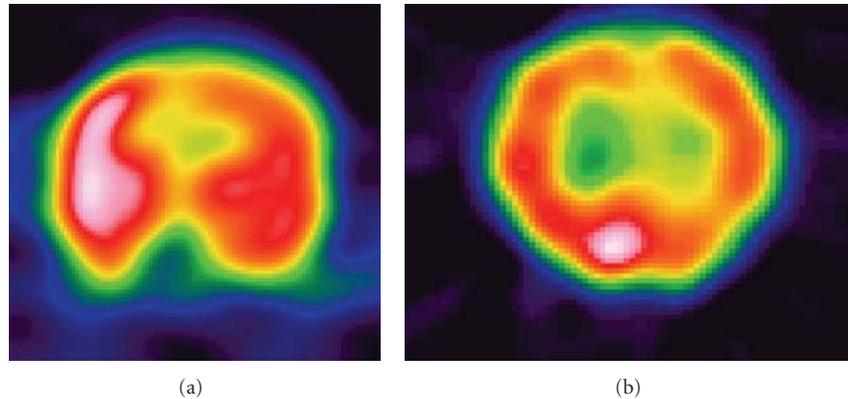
Ictal SPECT in extra temporal epilepsy showing (a) right frontal hyperperfusion in a patient with frontal lobe epilepsy (b) right occipital hyperperfusion in a patient with occipital lobe epilepsy.
